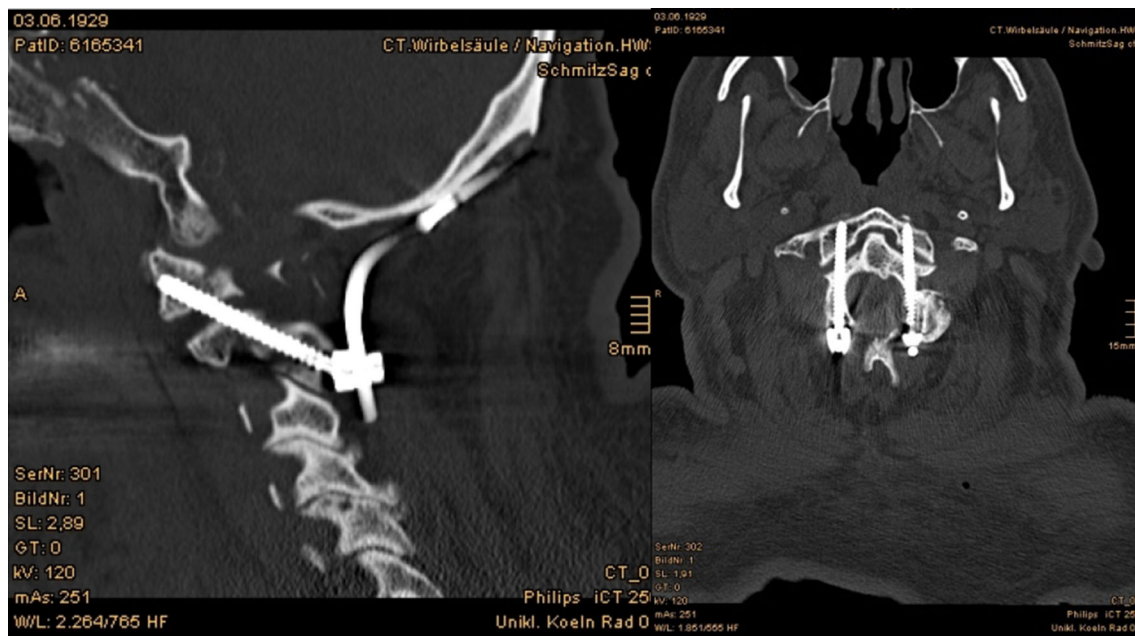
Postoperative CT scan in sagittal and axial planes, grade 1 in modified Gertzbein and Robbins classification
